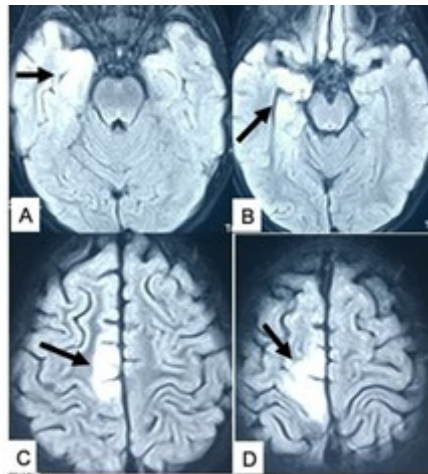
MRI of brain axial views in a 7-year-old girl with a history of birth asphyxia with intractable focal seizures: (A,B) showing right MTS (arrow indicated) and (C,D) showing right superior frontal focal CD (arrow indicated). Source: Figure by authors.
